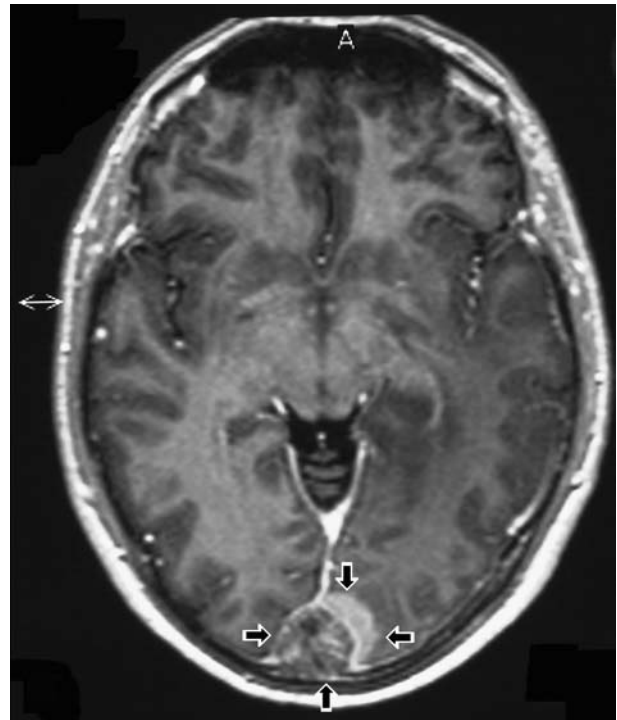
T1-weighted axial brain MRI with gadolinium showing tumor recurrence extended in sagittal sinus with associated thrombosis.
